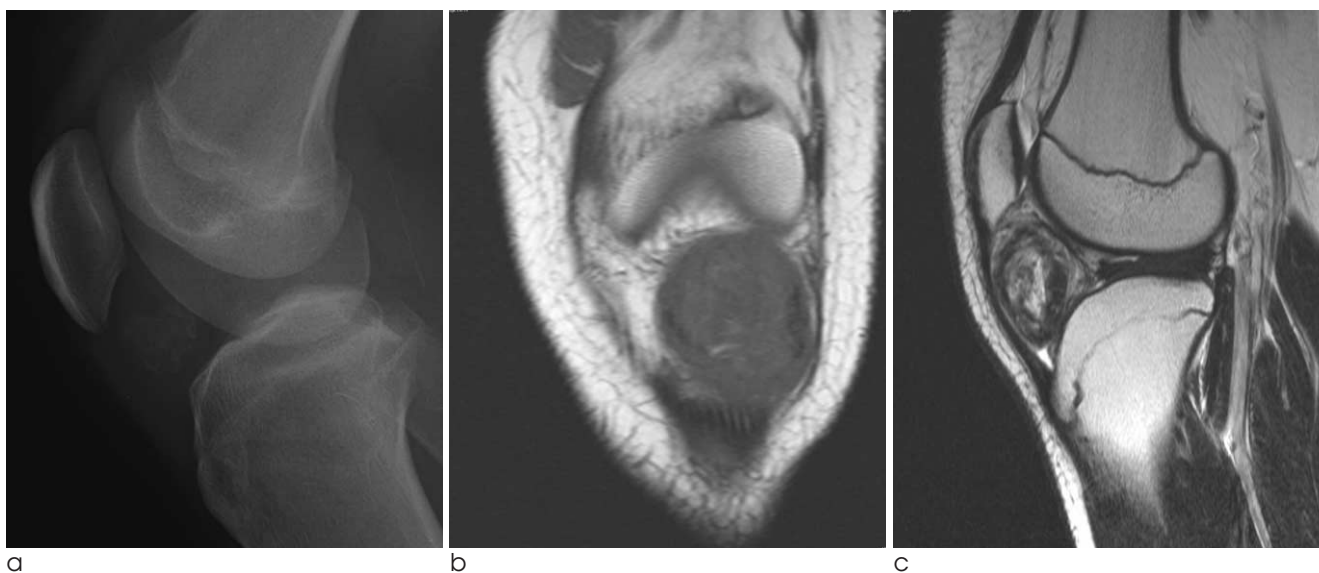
A 15-year-old woman with intracapsular or paraarticular chondroma on infrapatellar fat pad. a. Lateral radiograph of the knee shows an infrapatellar calcified soft tissue mass (white arrows). b. Coronal T1 weighted image shows intermediate to low signal intensity similar to surrounding muscle (black arrows). c. Sagittal T2 weighted image shows high signal intensity corresponding to areas of hyaline cartilage and low signal intensity corresponding to areas of calcified foci (arrowheads).
